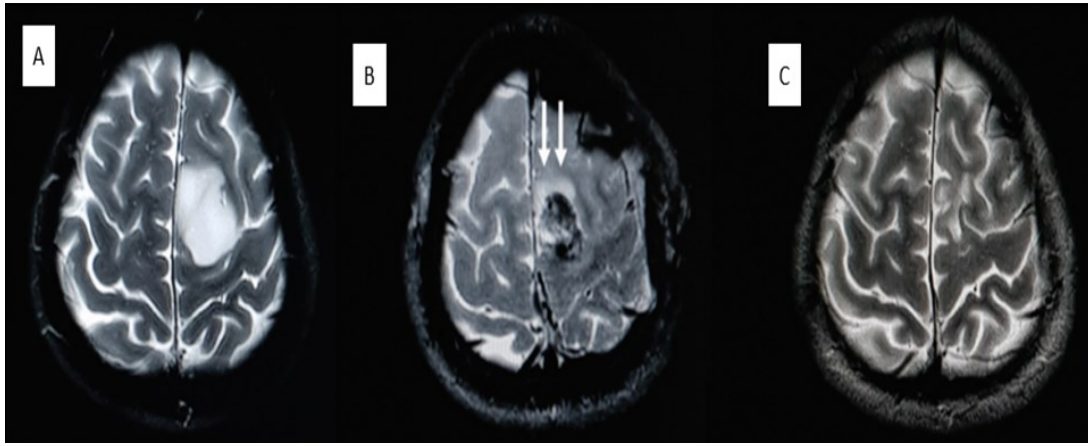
Example of images obtained preoperatively with assistance preoperative (A), intraoperative (B) and postoperative (C) MRI Source: [16].
